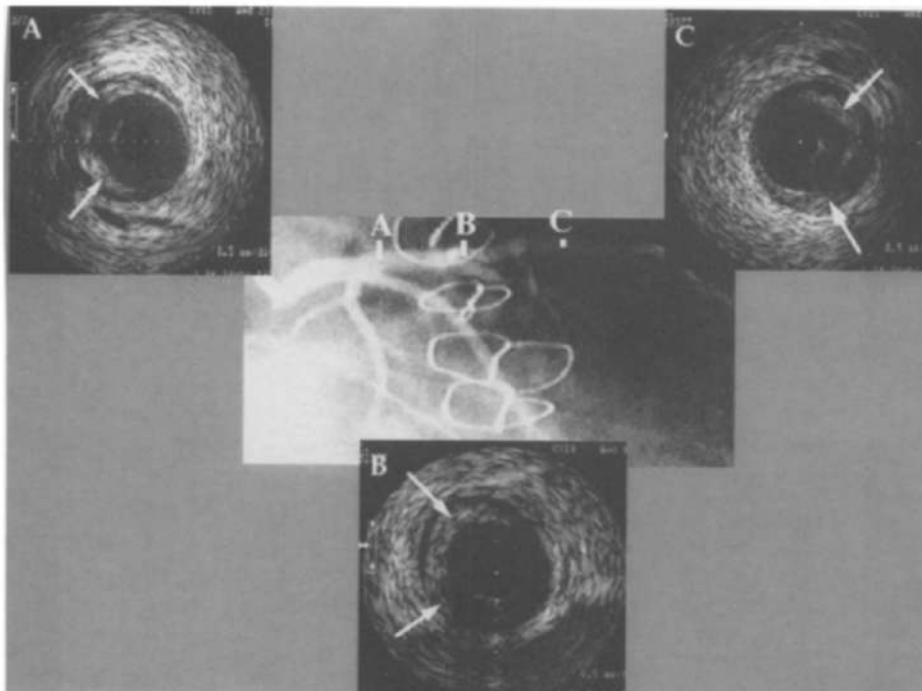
Example of diffuse longitudinal pattern of intimal thickening. Intracoronary ultrasound images (lettered, small panels) from three segments indicated on contrast coronary angiogram (corresponding letters, central large panel). Black circle in center (calibration dots at intervals of 0.5 mm) of each ultrasound image is imaging catheter. Circular lumen is slightly less black. Soft gray shadow of intimal thickening (small arrows) is outlined by darker stripe of more echolucent medial layer. Intimal thickening is severe (Figure 2) in all three segments and is classified as having diffuse longitudinal pattern. Note radiodense imaging unit in ultrasound catheter just below B on angiogram. Also note sternal wires on angiogram in patients after transplantation surgery. A, Site in more proximal segment; B, site in middle segment; C, site in more distal segment.
